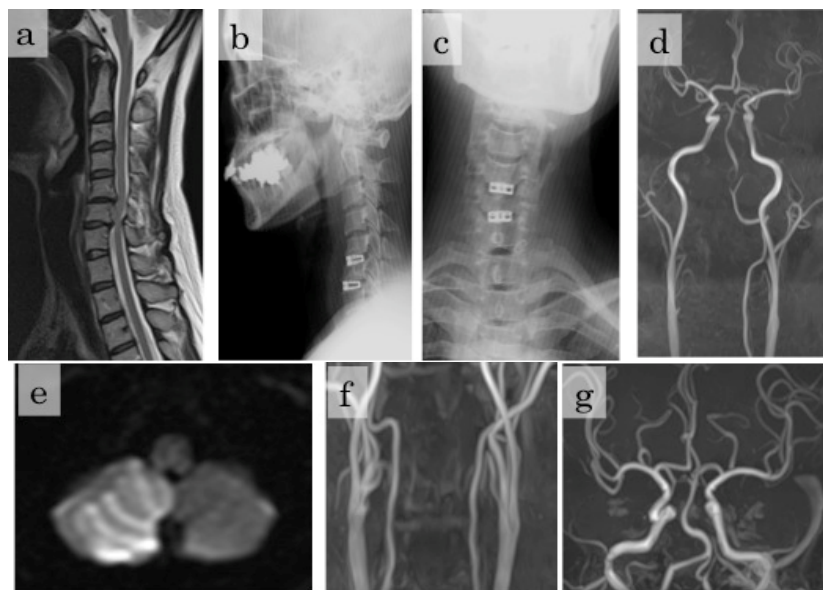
Preoperative cervical MRI (magnetic resonance imaging) demonstrating spondylotic changes at the level of C5-C6 and C6-C7 (a), Lateral and (b), Anteroposterior (A-P) view of immediate postoperative cervical radiography demonstrating titanium cages appropriately placed at C5-C6 and C6-C7 (c), Cervical and cranial MR angiography 2 days after surgery demonstrated right vertebral artery occlusion (d), Diffusion-weighted MRI 2 days after surgery demonstrated cerebellar infarction in the right cerebellar lobe (e), Cervical (f) and Cranial MR angiography 2 two years after discharge revealed complete recanalization of right vertebral artery (g).
